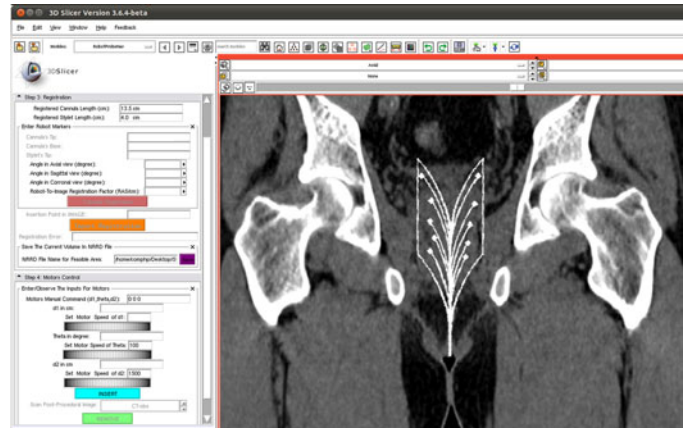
Registered 3-D feasible volume is aligned on the prostate image demonstrating a transperineal prostate therapy case. The multiple paths are visualized using inverse kinematics. The left side shows part of the widgets designed in 3-D Slicer for importing the needle specifications, the registration parameters, and the motor commands. The CT image is taken from [72].
